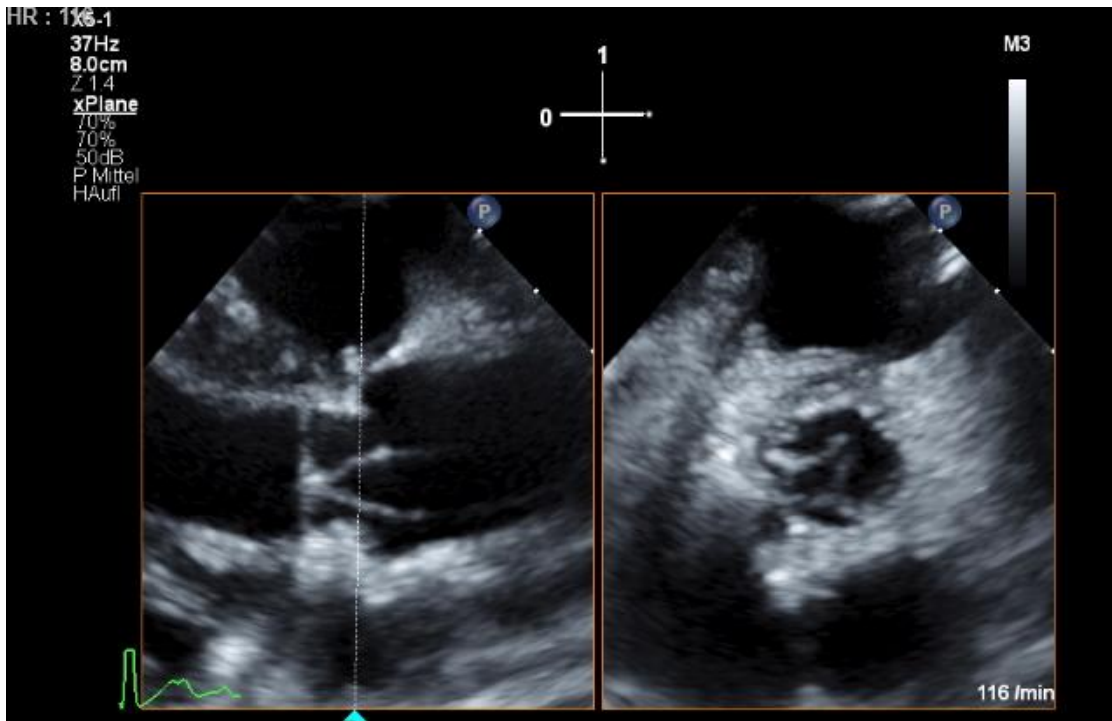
Early postoperative biplane transthoracic echocardiography
